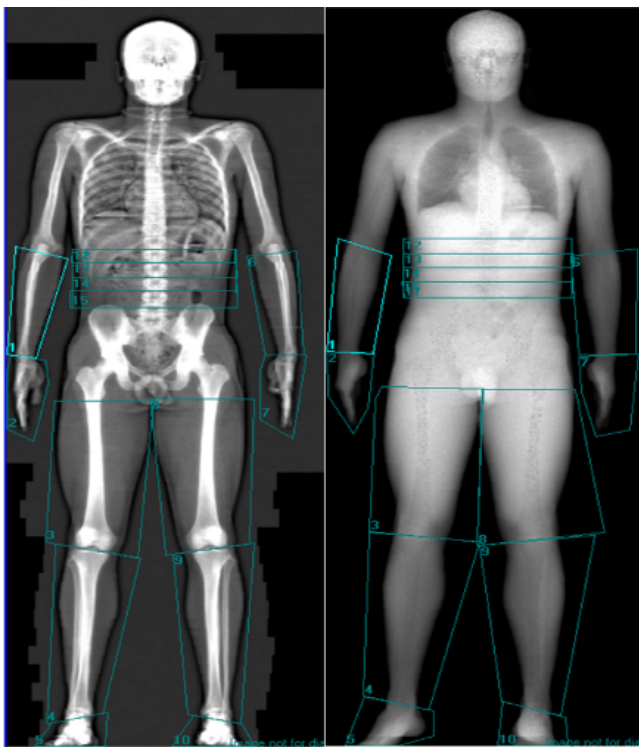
Body composition assessment using Dual X-Ray Absorptiometry.
